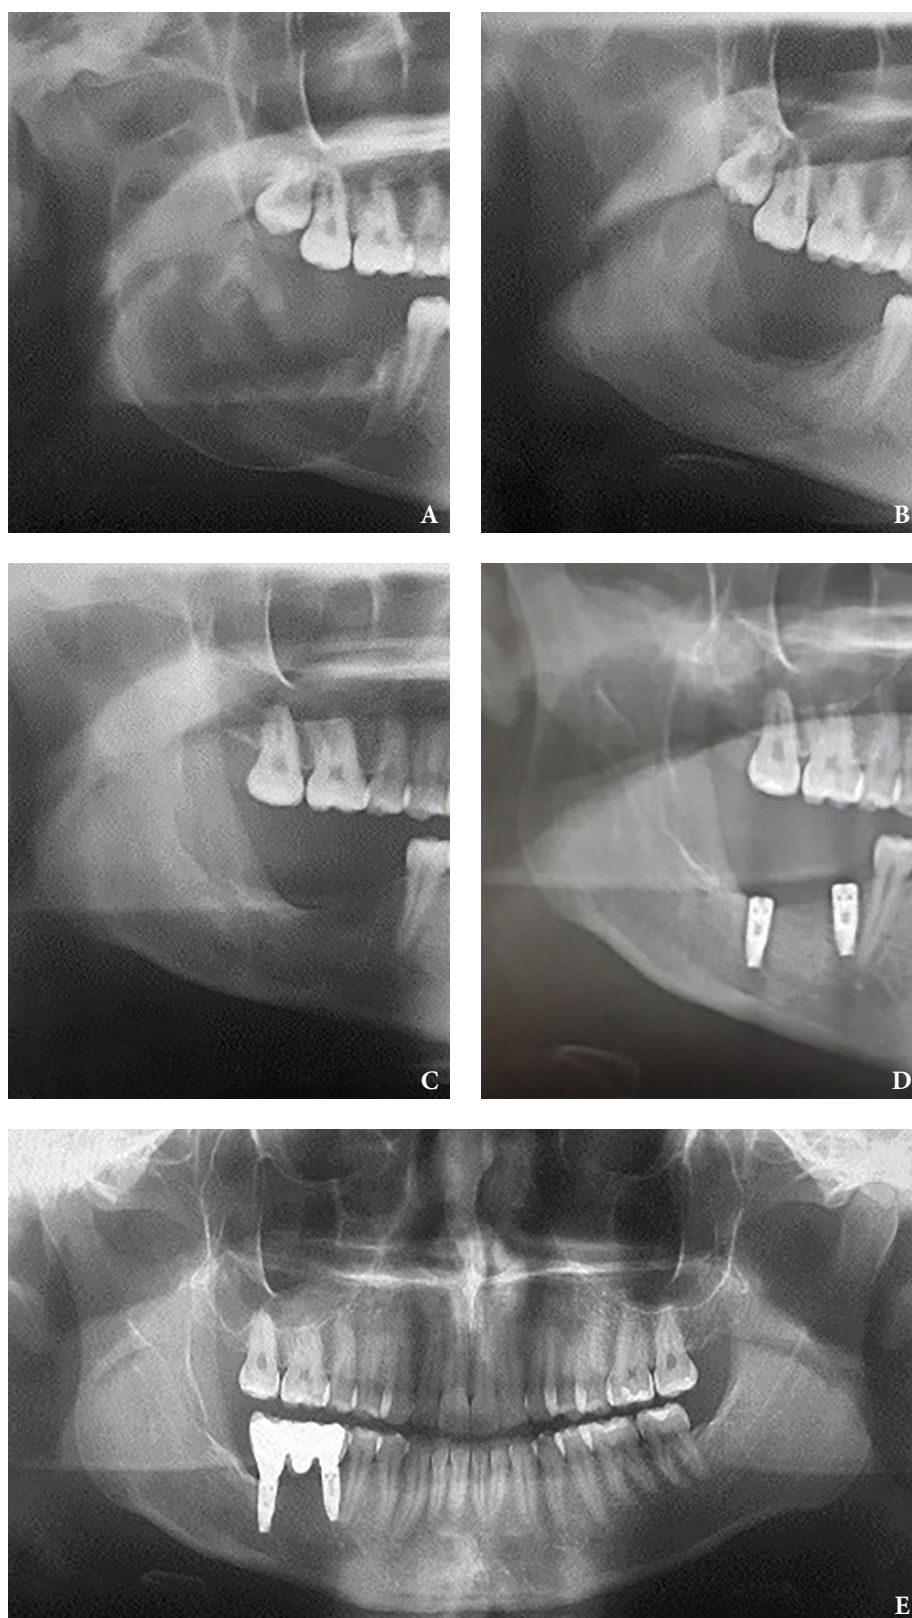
Case 2: Panoramic radiography. A: 3 months post-op. B: 6 months post-op. C: 1 year post-op. D: 2 years after the surgical procedure, osseointegration. The implants are placed for aesthetic and functional requirements of antagonistic teeth. E: 4 years post-op.
